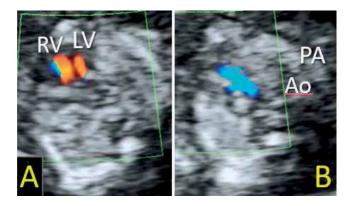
Hypoplastic left heart. A diminutive left ventricle (A) and aorta (B) are identified with the aid of color Doppler. RV, left ventricle; LV, left ventricle; PA, pulmonary artery; Ao, aorta.
